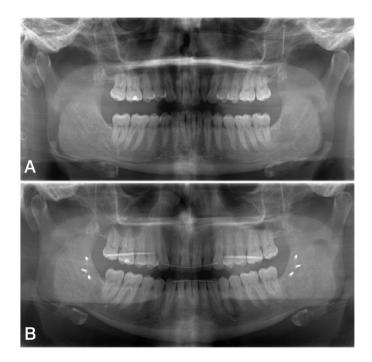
(A) Pre-operative orthopantomogram. No pathology is visible. (B) Postoperative orthopantomogram 1 year after surgery. Fixation screws still in place. The joints retain a normal aspect.
